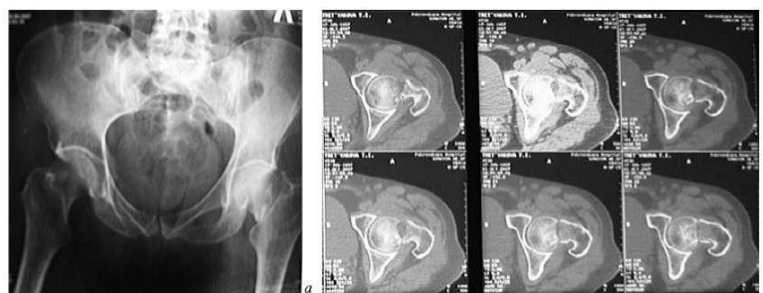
Radiological examination of B. T. before surgery: a - radiological examination - a medial fracture of the neck of the left femur was revealed; b — CT scan — the subcapital nature of the fracture is clarified.
